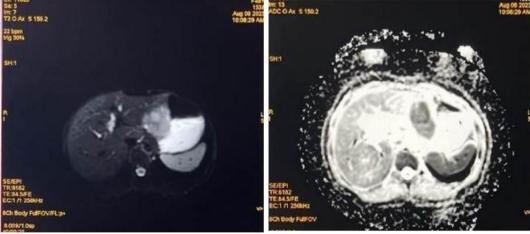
DWI and corresponding ADC, showing patchy diffusion restriction of the lesion.
